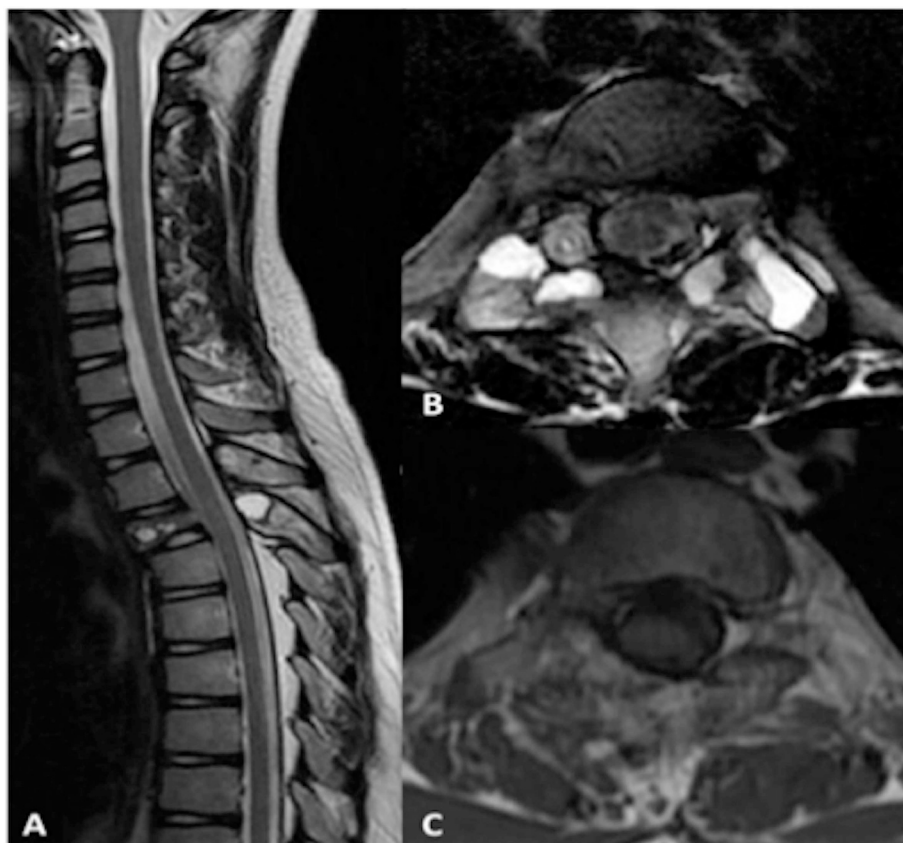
Monitoring MRI-scan AT 1 year. A) Sagittal and Axial level-T4, T2 SE sequence showing a significant reduction in the aneurysmal cystic lesions of which some cyst-like spaces persist within the posterior arch of T4. Same level axial T1SE showing intra-cyst modification suggesting sclerosis processus with reossification and reconstitution of the cortical bone and in particular a clear reduction in the component responsible for the initial spinal compression. At the bottom row, Sagittal T2 STIR comparison at one year from treatment showed more than 7 mm of spinal canal widening at T4-level.
